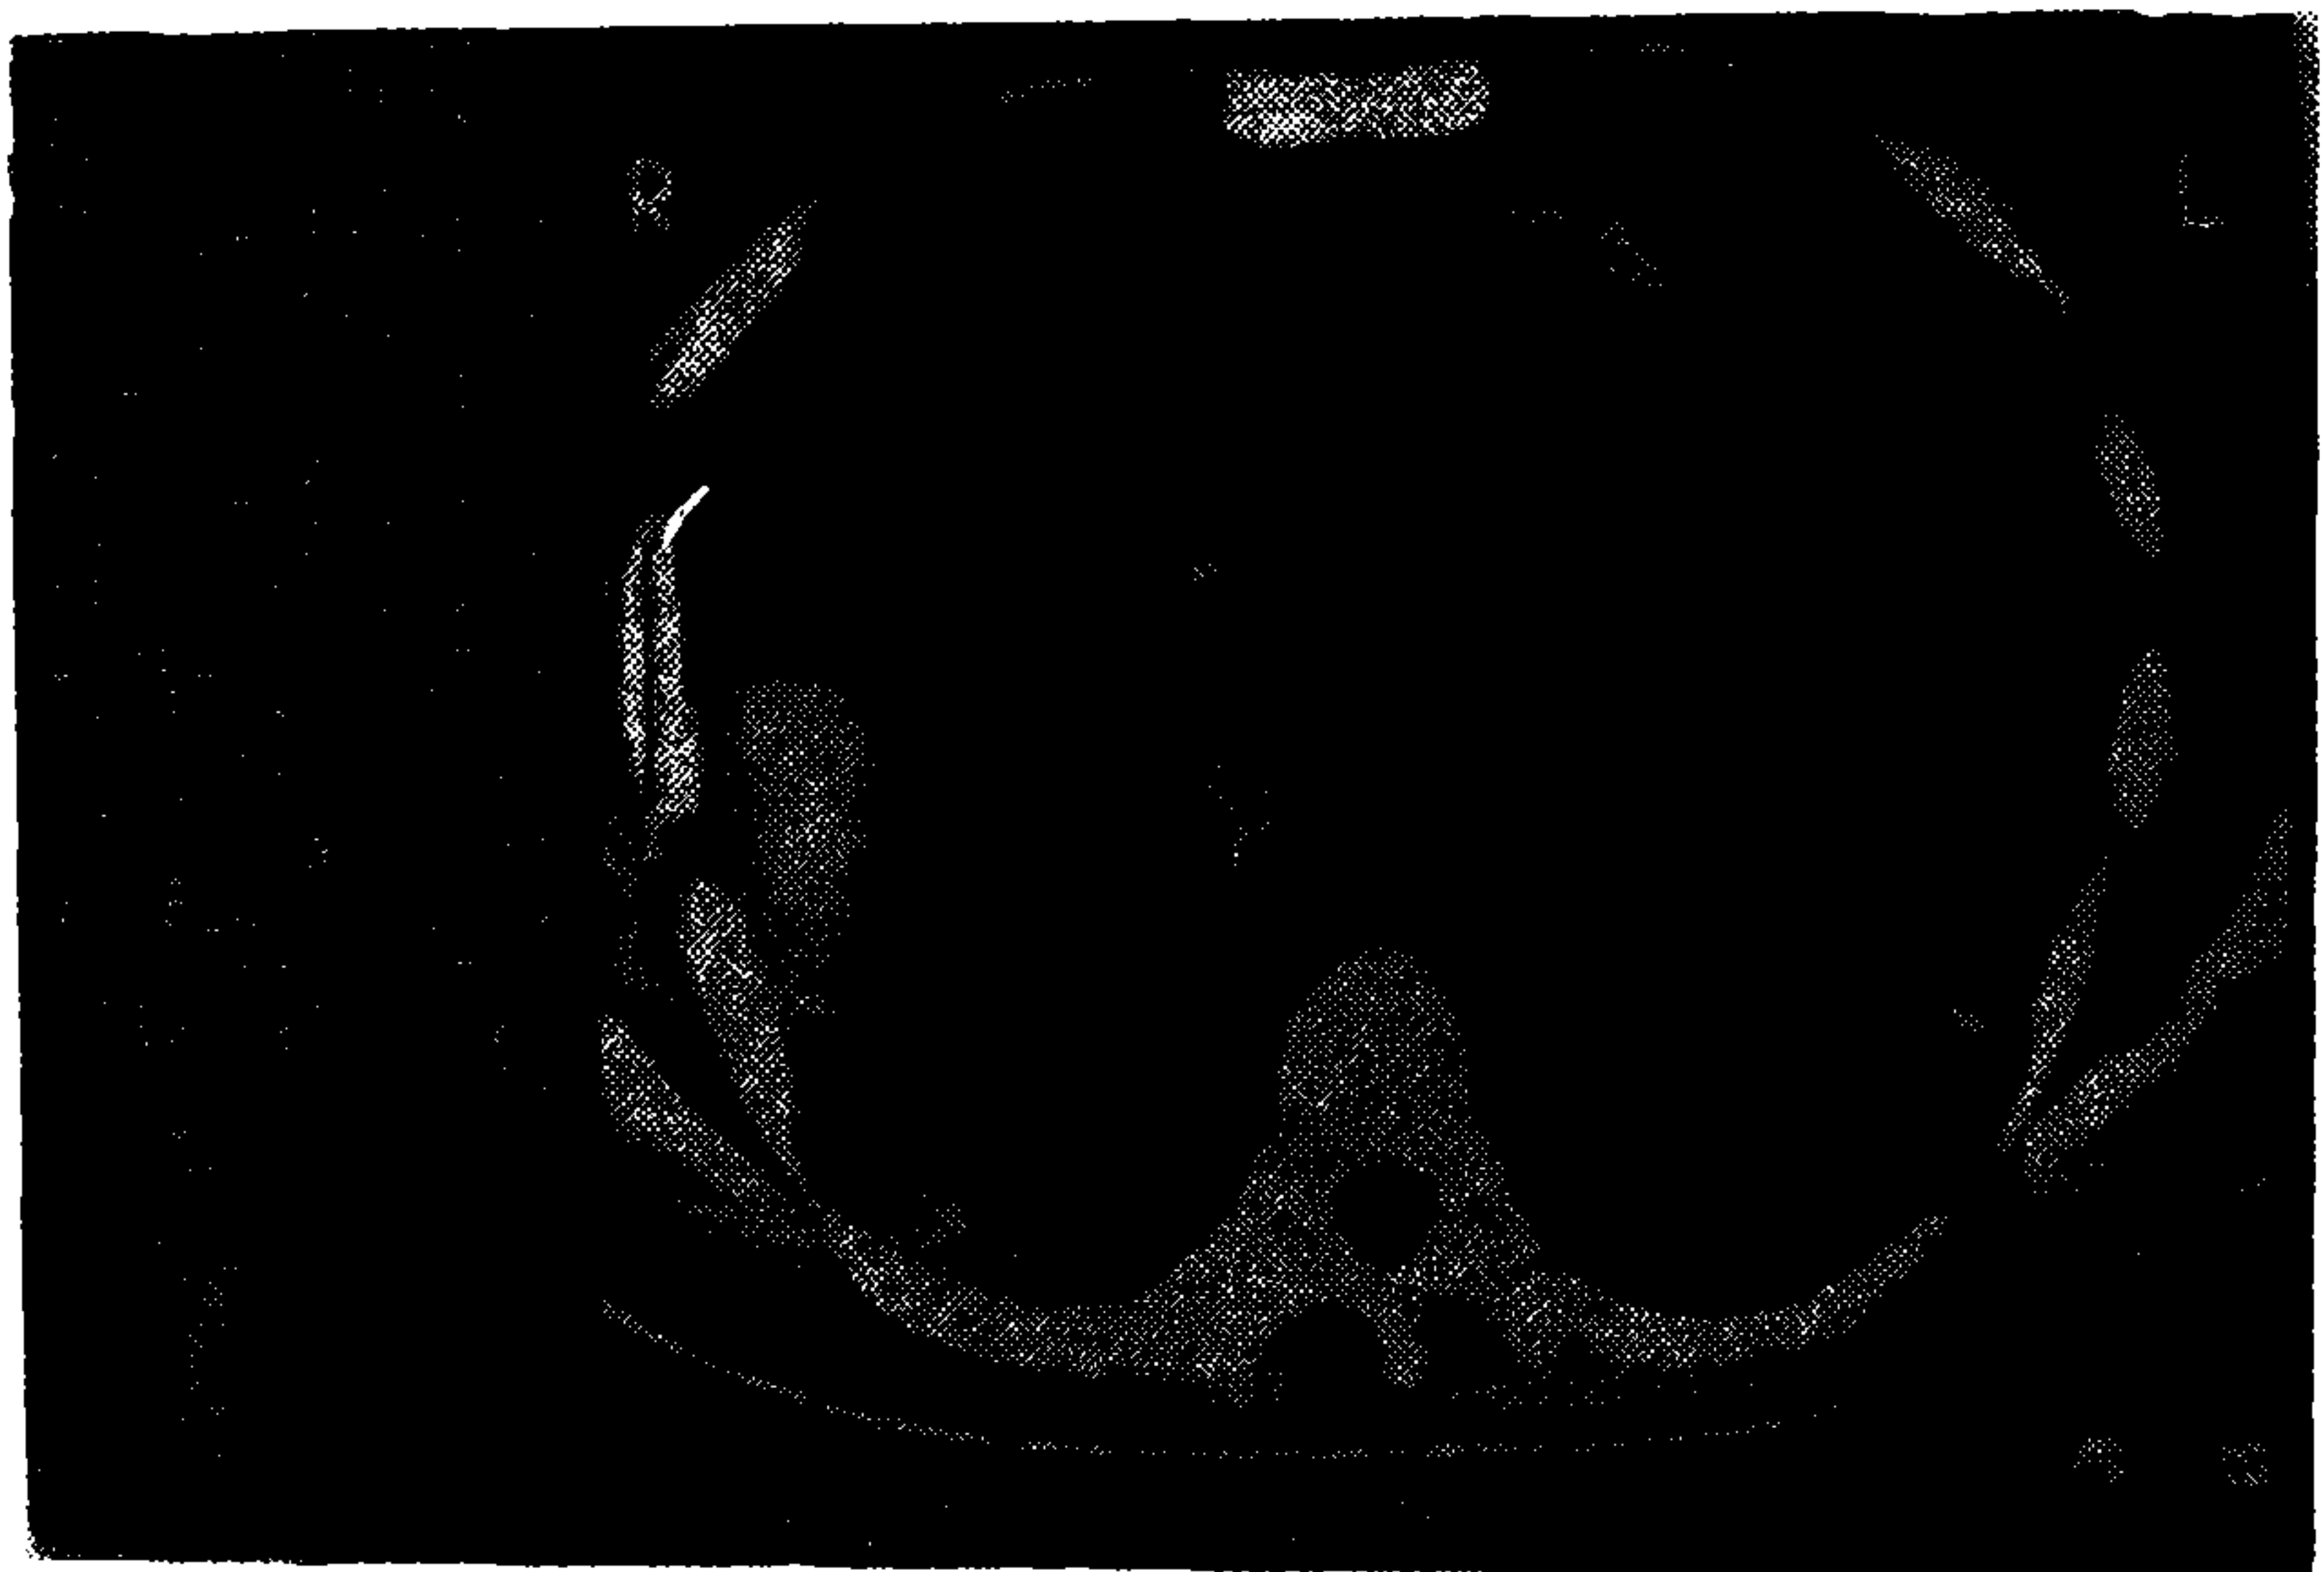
Computed tomographic examination of the patient revealed a huge mass starting from subcarinal region and extending through the posterior mediastinum. It seems to be encapsulated. The mediastinal mass computed 23-42 Hounsfield unit.
